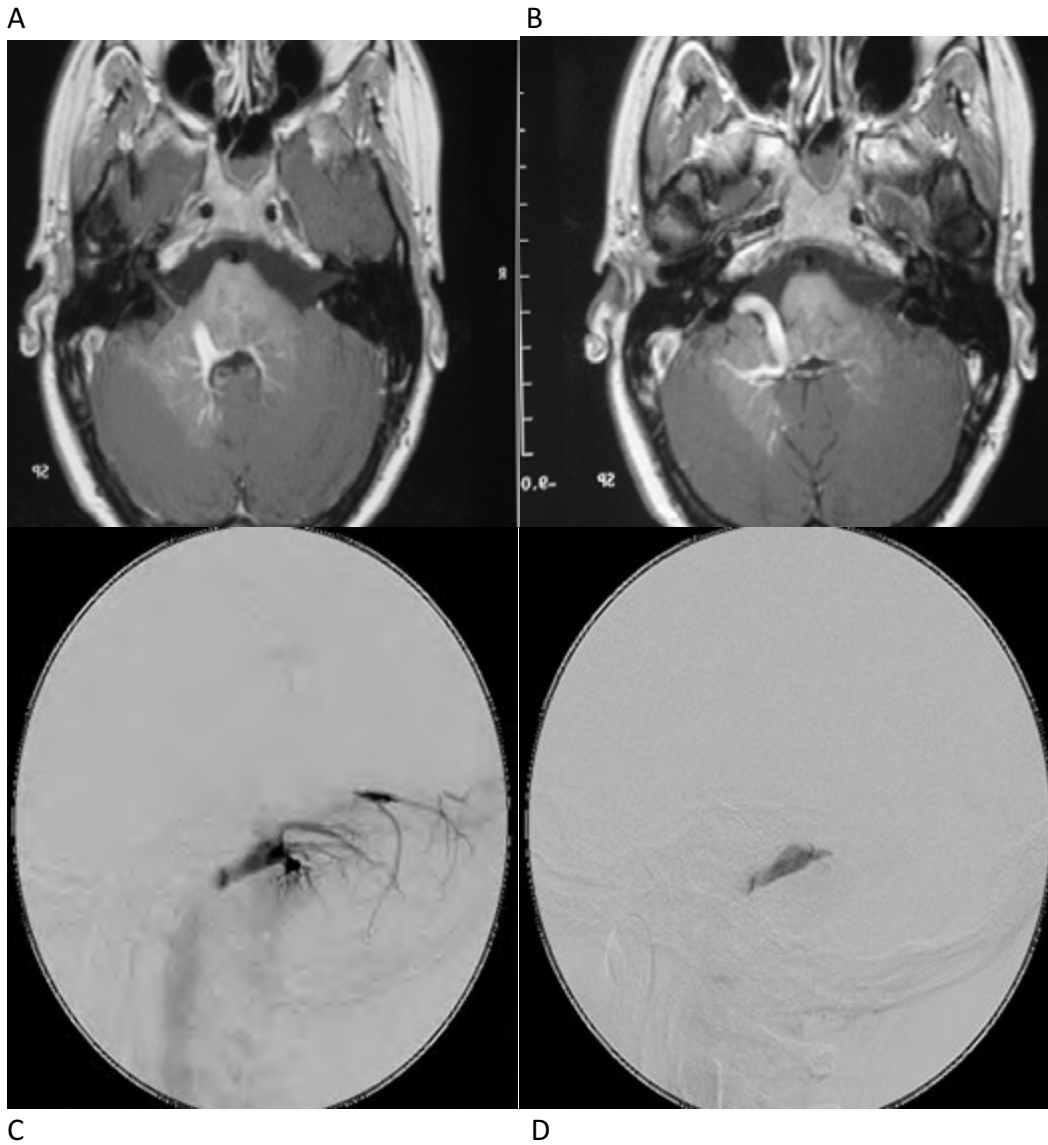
24-year-old female presented with progressive leg spasticity. A and B magnetic resonance imaging (T1-weighted with gadolinium, axial) large right DVA draining the pons and right cerebellar hemisphere with increased signal in the pons and the cerebellar hemisphere. C Angiography showed the DVA with a large collecting vein drain into the jugular bulb with stenosis at the point it entered the dura. D Angiography showing a long delay in the emptying of the DVA.
